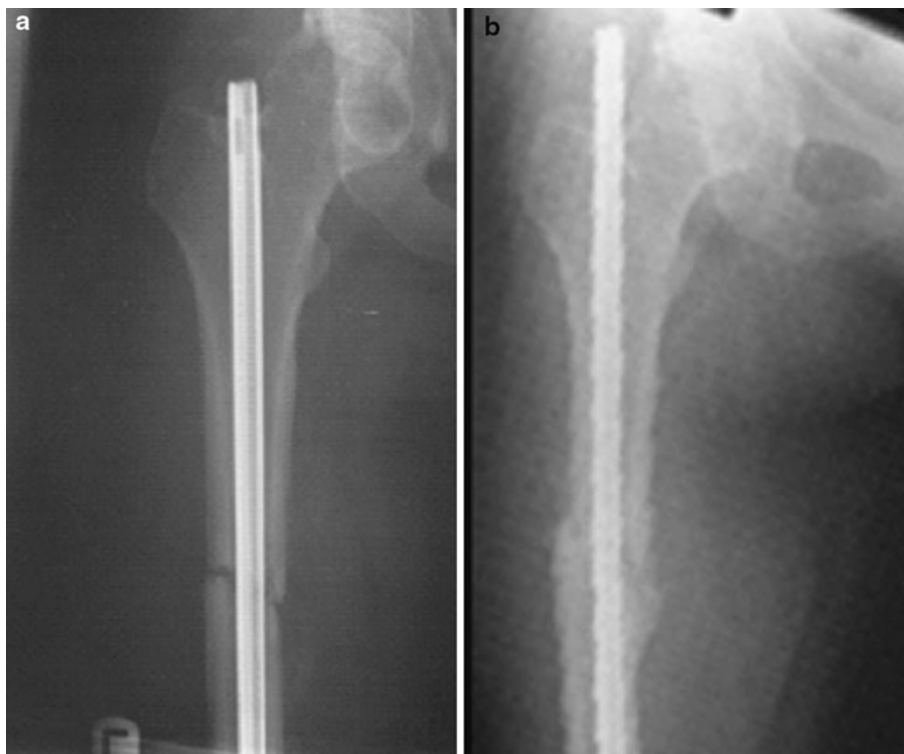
a Pre-operative X-rays of case 1. b Post-operative X-rays of case 1 (16 weeks post-operation)
